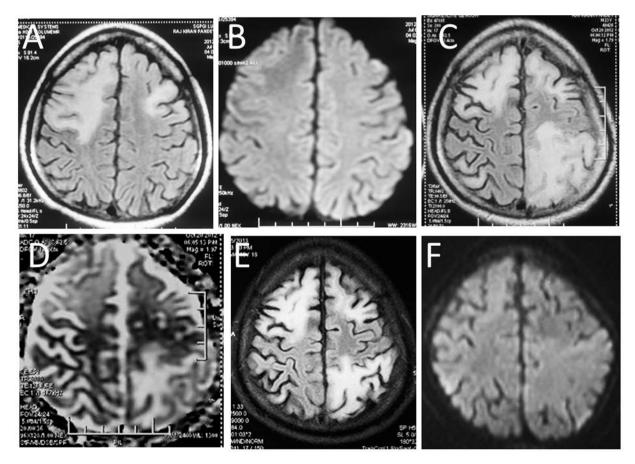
MRI of patient #1. A and B are baseline MRI images showing right frontal hyper intense lesion on FLAIR but DWI did not show restriction. C and D are repeat MRI after 2 months of penicillamine when he had worsening. There are additional new lesions in left parietal region on FLAIR (C) and the left parietal lesion revealed restricted diffusion on DWI (D). E and F are MRI at 6 months and revealed mild regression of lesion on FLAIR (E) and these lesions did not reveal restriction on DWI (F).
